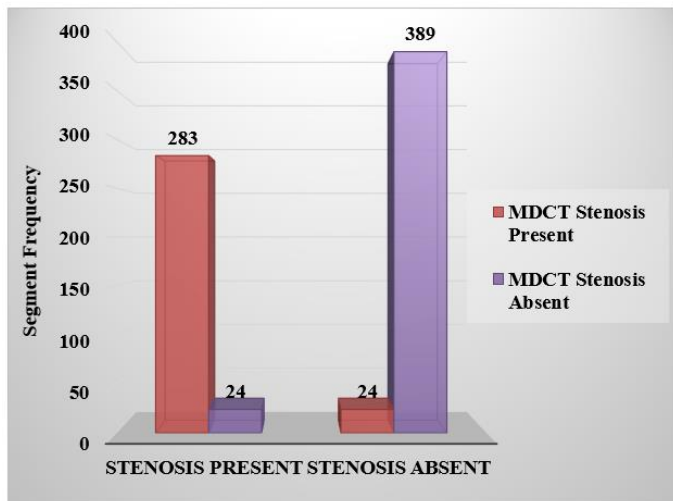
Comparison of color doppler finding with MDCT for lower limb arterial stenosis
